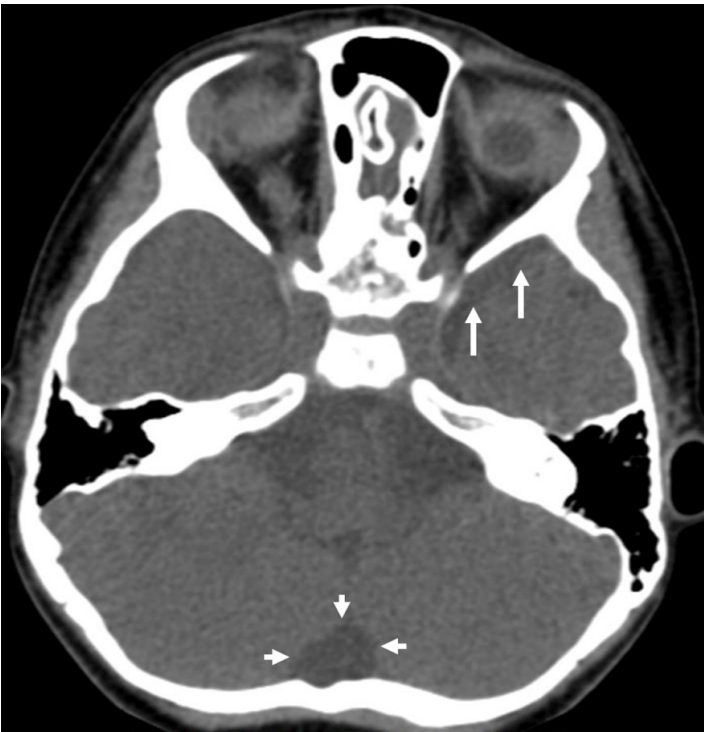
Axial CT image demonstrates arachnoid cysts located in the middle (long arrows) and posterior (short arrows) cranial fossa
